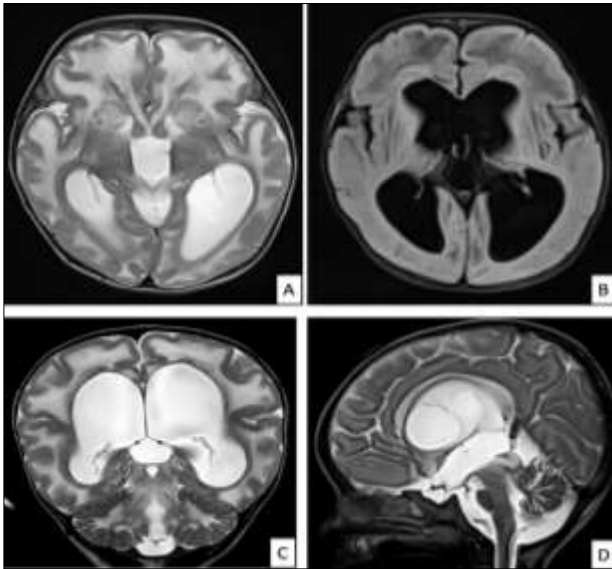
(A) Axial T2WI, (B) axial FLAIR image - showing abnormal high signal intensity in white matter of bilateral frontal and temporal lobes, heads of caudate nuclei and midbrain with dilated bilateral lateral and third ventricle, (C) coronal T2WI - ventriculomegaly is noted along with hyperintense signal in white matter in bilateral cerebral and cerebellar hemispheres, and (D) sagittal T2WI - high signal intensity is noted in the dorsal brainstem.
